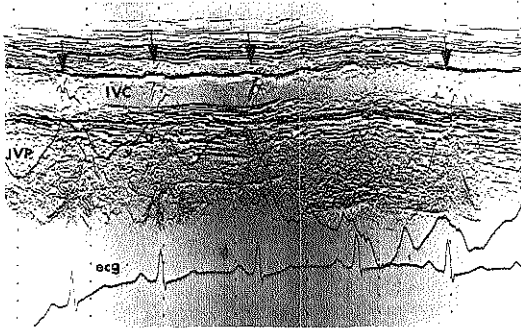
M*-mode contrast inferior vena cava (IVC) echocardiogram showing an *a*-wave synchronous pattern in a patient with pulmonic stenosis and no tricuspid pathology. The jugular venous pulse tracing (JVP) shows a large respiratory variation but always a prominent "a" wave and *x'* descent, making significant tricuspid regurgitation unlikely. Contrast appears in the IVC (arrows) during the late part of the JVP "a" pulsation, suggesting retrograde flow due to forceful atrial contraction. *a* = "a" pulsation; *v* = "v" pulsation.
